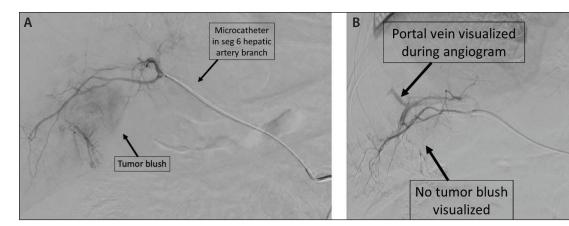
Initial Tc99m-MAA mapping selective angiography at 0.5 mL/second for 10 seconds of contrast demonstrated adequate perfusion to the tumor (A), which was confirmed with CBCT (not pictured). During the subsequent radioembolization procedure, selective angiography showed an APS (top arrow) diverting flow away from the tumor (B).
